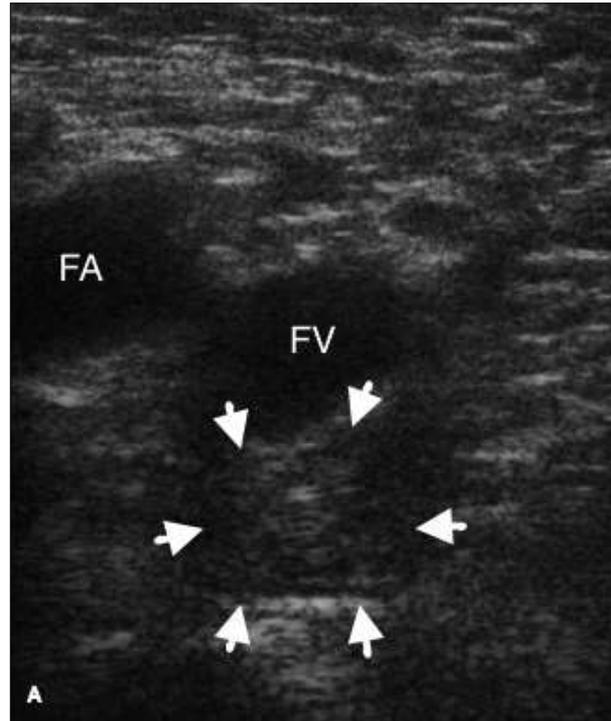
A, Transverse sonogram without the Valsalva maneuver. Fat herniation (arrows) is shown on the medial and inferior aspect of the femoral vein (FV). FA indicates femoral artery. B, Transverse sonogram with the Valsalva maneuver. Fat herniation (arrows) into the femoral canal accentuates and completely effaces the femoral vein.
